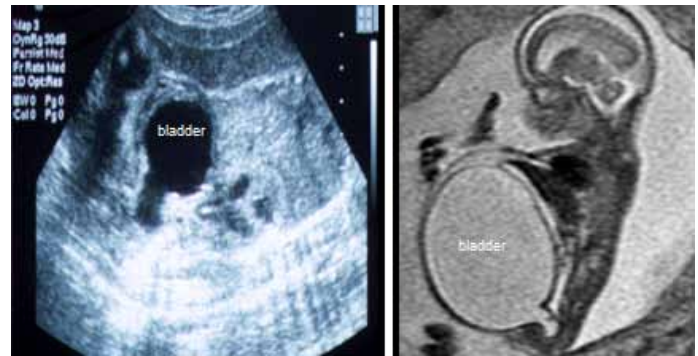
US scan (left) and MRI (right) of posterior urethral valves.
